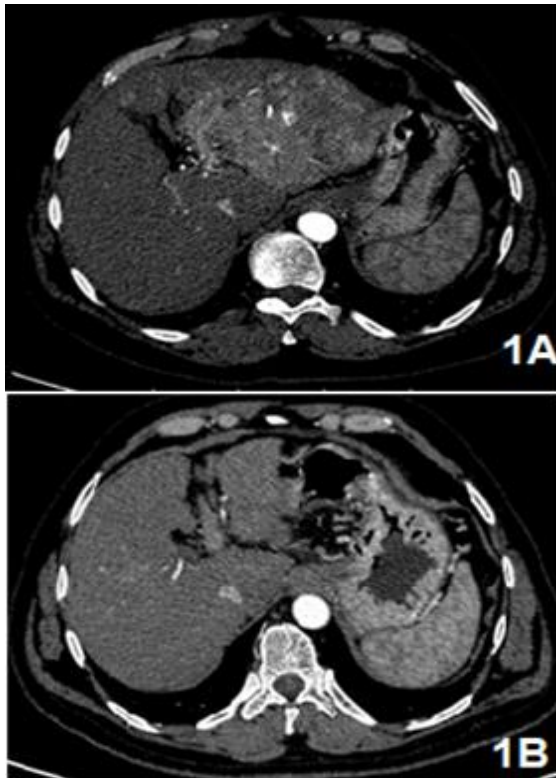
shows complete post-Sorafenib HCC response in a 54 years old female patient. 1A: Pre Sorafenib Axial slice through the triphasic CT scan in the arterial phase shows infiltrating left lobe HCC with arterialized tumor thrombus in left portal vein. 1B: Post sorafenib axial slice on the follow up triphasic CT scan at same level in arterial phase shows the disappearance of arterialization in left lobe tumor and adjacent left portal vein tumor thrombus.
